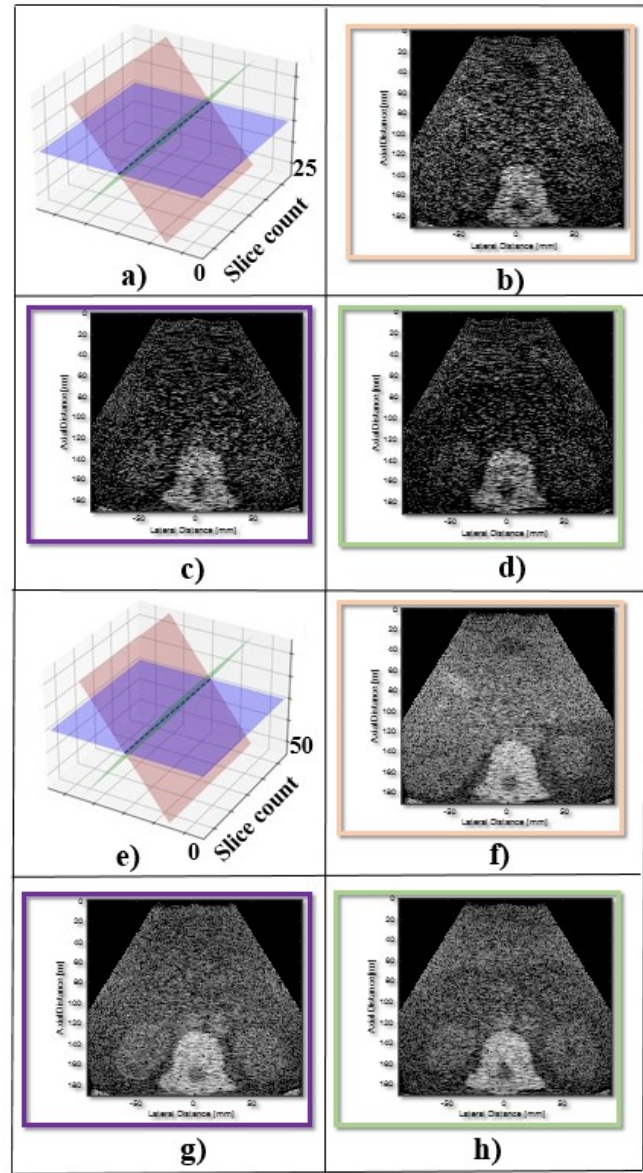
(a) Shows ultrasound volumetric data formed from the original 25 CT slices, (b) Ultrasound image formed from the slice shown in orange in (a), (c) ultrasound image formed from the slice shown in blue in (a), (d) ultrasound image formed from the slice shown in green in (a), (e) denser ultrasound volumetric data formed from ultrasound images corresponding to 50 CT slices, (f) ultrasound image formed from the slice shown in orange in (e), (g) ultrasound image formed from the slice shown in blue in (e), and (h) ultrasound image formed from the slice shown in green in (e).
